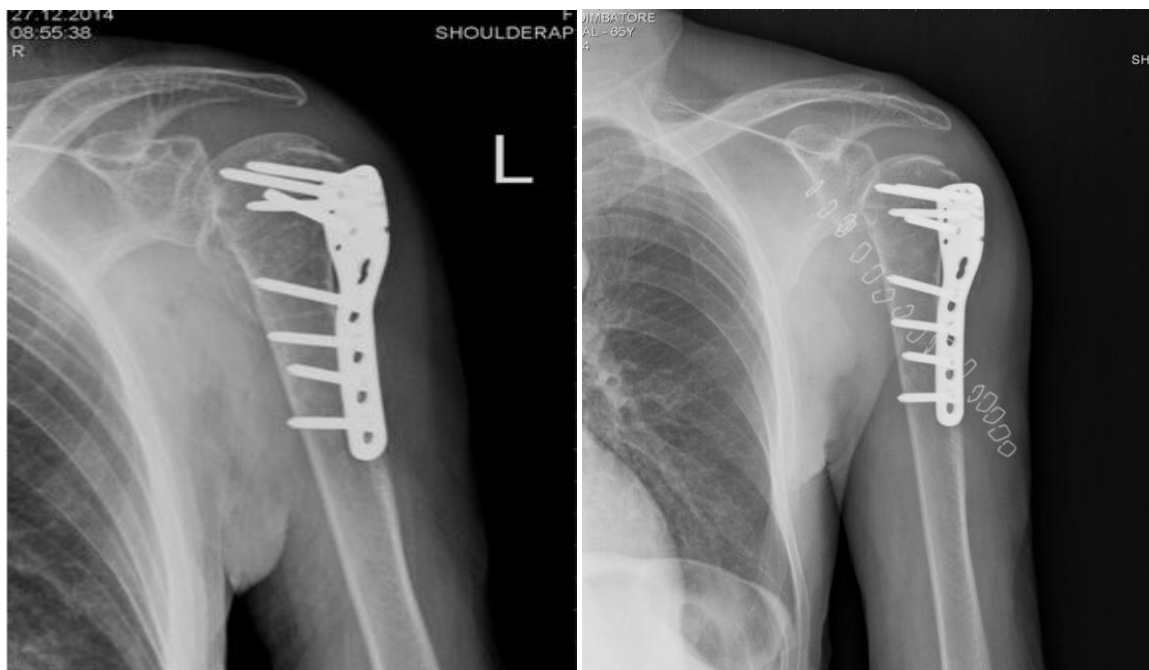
Post -Operative X-ray.
